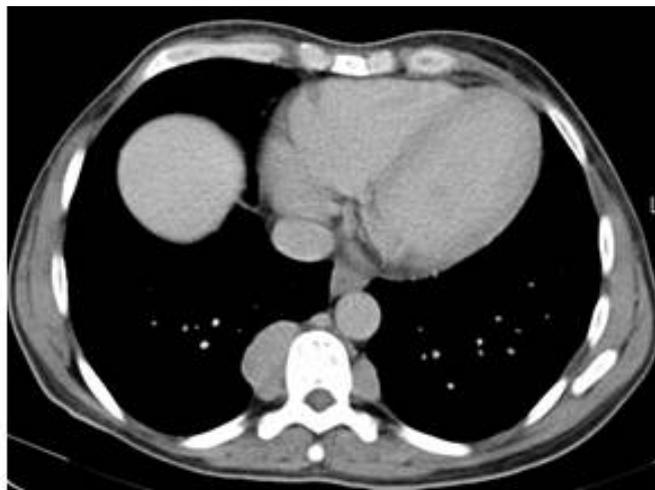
CT thorax - bilateral paravertebral tissue mass, maximum size on the right side (44/23 mm) (coronal section – left image, and cross section – right) – Dr. RusuMunteanu Gina, Fundeni Clinical Institute
